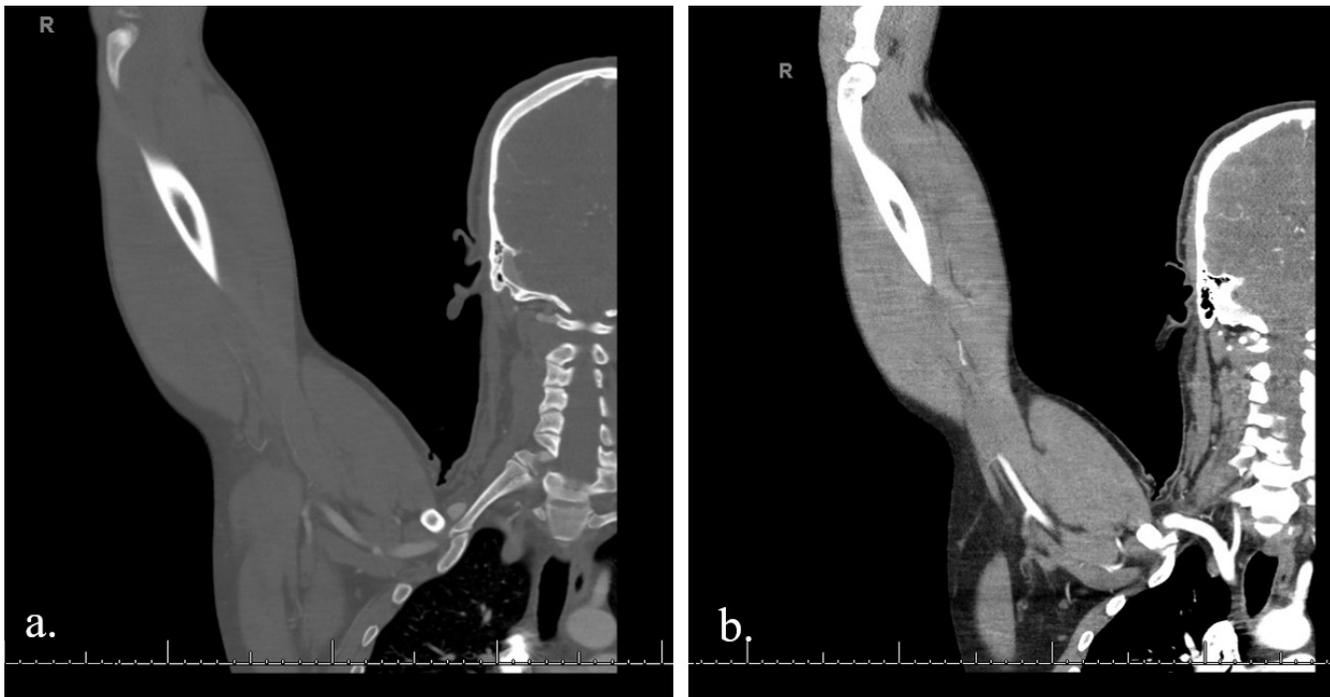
Coronal cuts from computed tomography angiography demonstrating right accessory cervical rib leading to narrowing of the thoracic outlet (a) and thrombosis leading to complete occlusion of the proximal right brachial artery (b).
